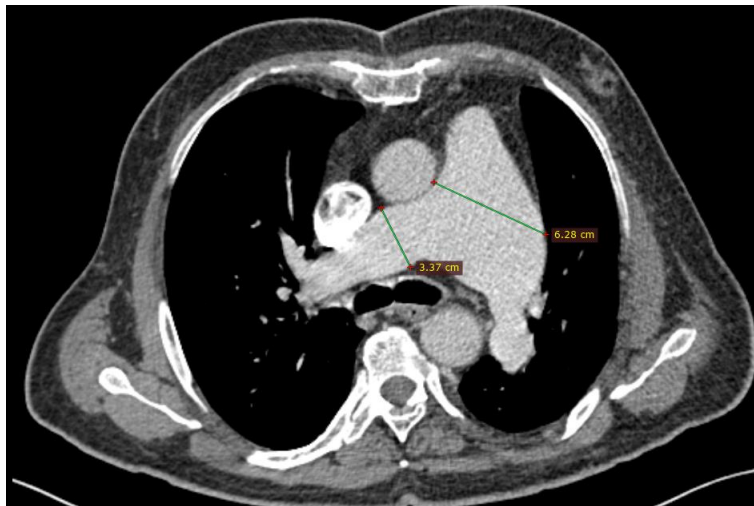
Computed tomography scan showing dilatation of the trunk of the pulmonary artery and its right branch. The ratio of the diameter of the pulmonary artery to that of the aorta is greater than two
